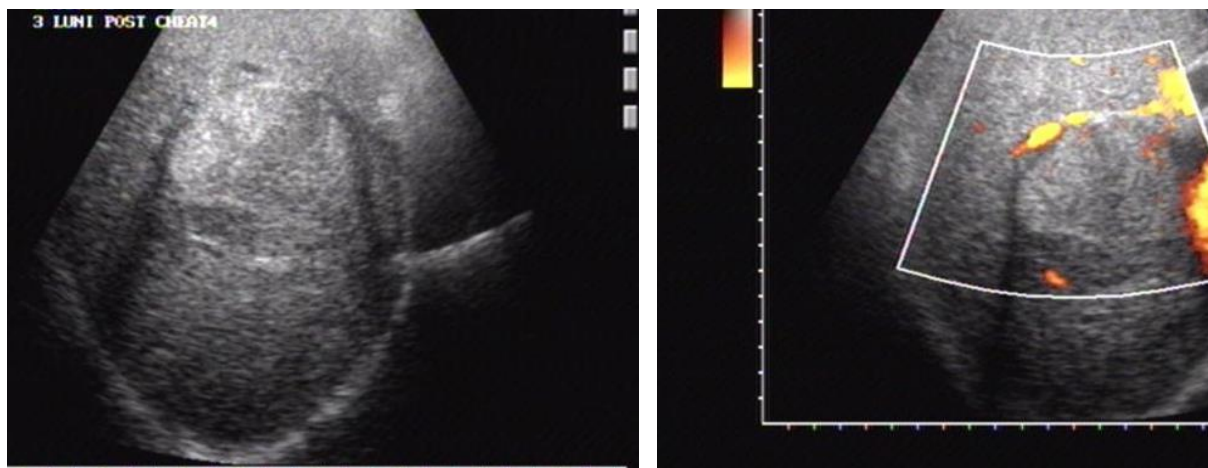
a) Liver US: HCC; b) Follow-up y Doppler ultrasound revealed diminished intratumoral vascularization, with persistence of peripheral vascularization.
